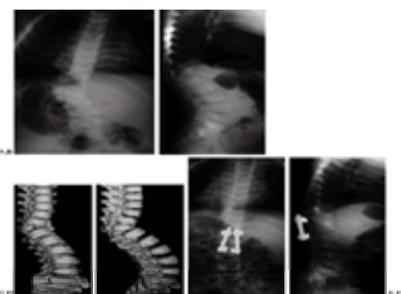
A: Preoperative radiograph in a 6-year-old male with progressive congenital scoliosis due to an apparent T12 hemivertebra. B: Lateral view demonstrates focal kyphosis centered at the T12 level. C: Anterior view on a three-dimensional CT study demonstrates that the hemivertebra may have a small “butterfly” component (small residual of body on the opposite side). The absence of body anteriorly is leading to severe kyphosis. D: Sagittal view on three-dimensional CT study. The cause of the kyphosis is clear. E: PA radiograph after vertebral body excision and corrective instrumentation. F: Lateral view after vertebral body excision and corrective instrumentation.
